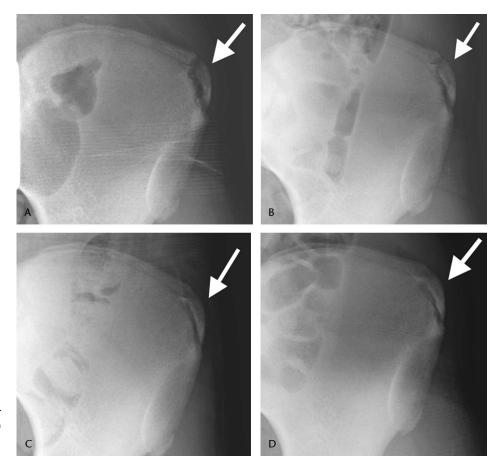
Case 1. Anteroposterior pelvis radiographs at initial visit (A) and at 2-month (B), 4-month (C), and 6-month follow-up (D).
